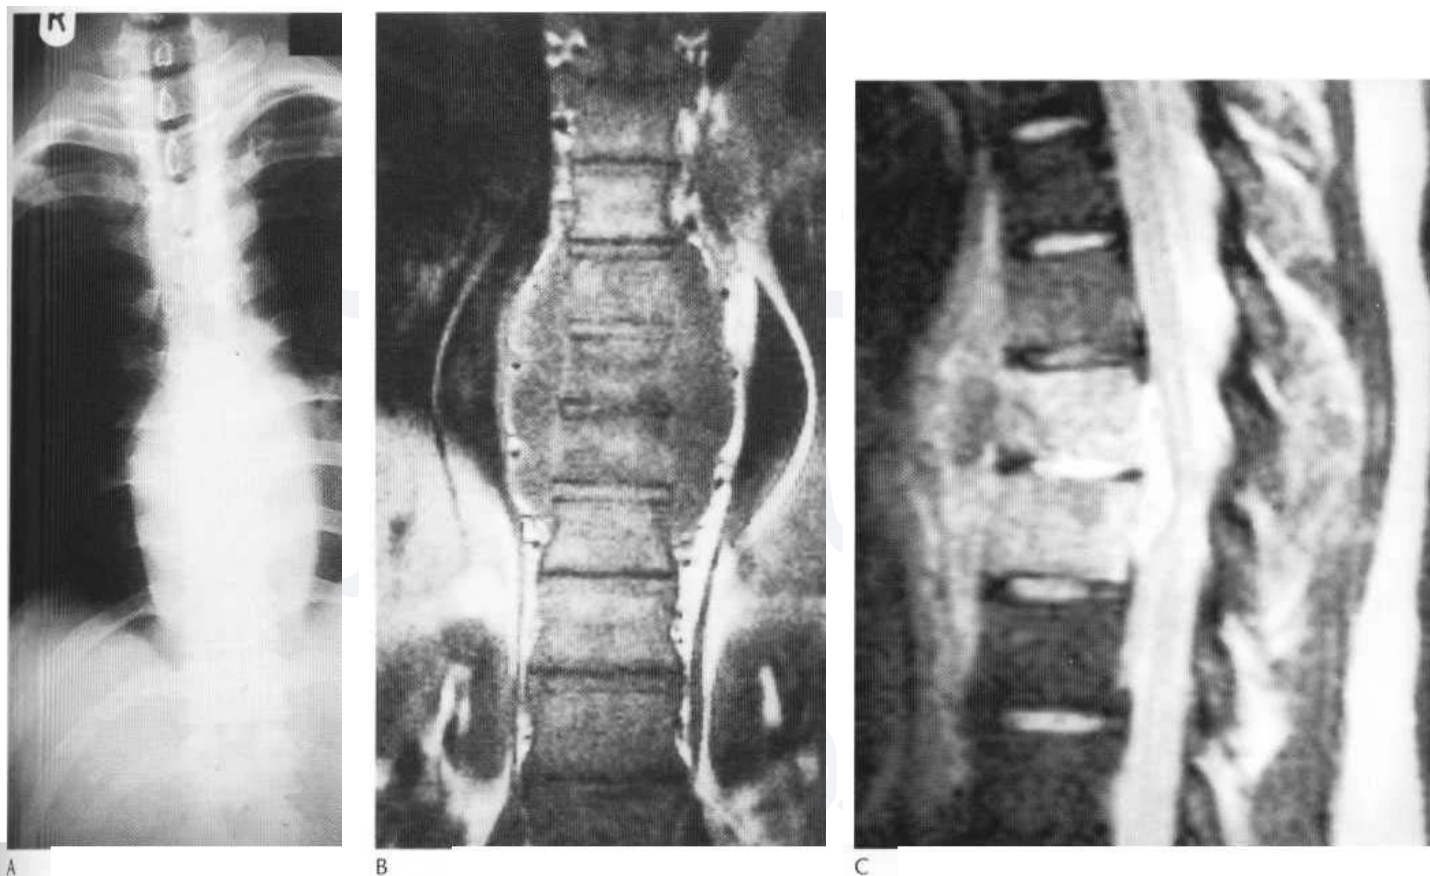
(A) The plain film shows features which are typical for spinal tuberculous disease. There is an extensive paraspinal soft-tissue mass. Detail in the underlying spine is poor but there is early crowding of ribs posteriorly, indicating early vertebral collapse. (B) Coronal MR image of the thoracic spine demonstrates destruction of the intervertebral disc at the point where the paraspinal widening is maximal and this change is associated with alteration of signal from the vertebrae. (C) The sagittal fat-suppression image shows increase in signal in adjacent vertebral bodies together with anterior and posterior soft-tissue masses, the latter indenting the spinal canal and compressing the adjacent cord.
